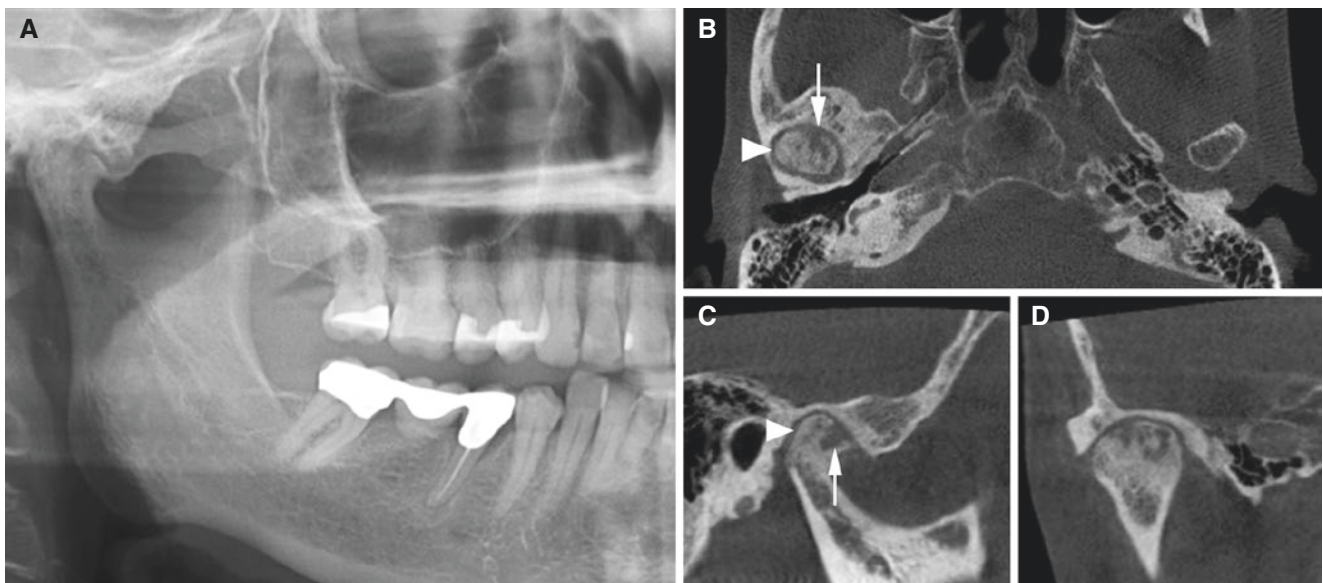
Rheumatoid arthritis; 59-year-old female with variable right-sided TMJ pain and mouth-opening problems. (A) Panoramic view and (B) axial, (C) oblique sagittal, and (D) oblique coronal CBCT
